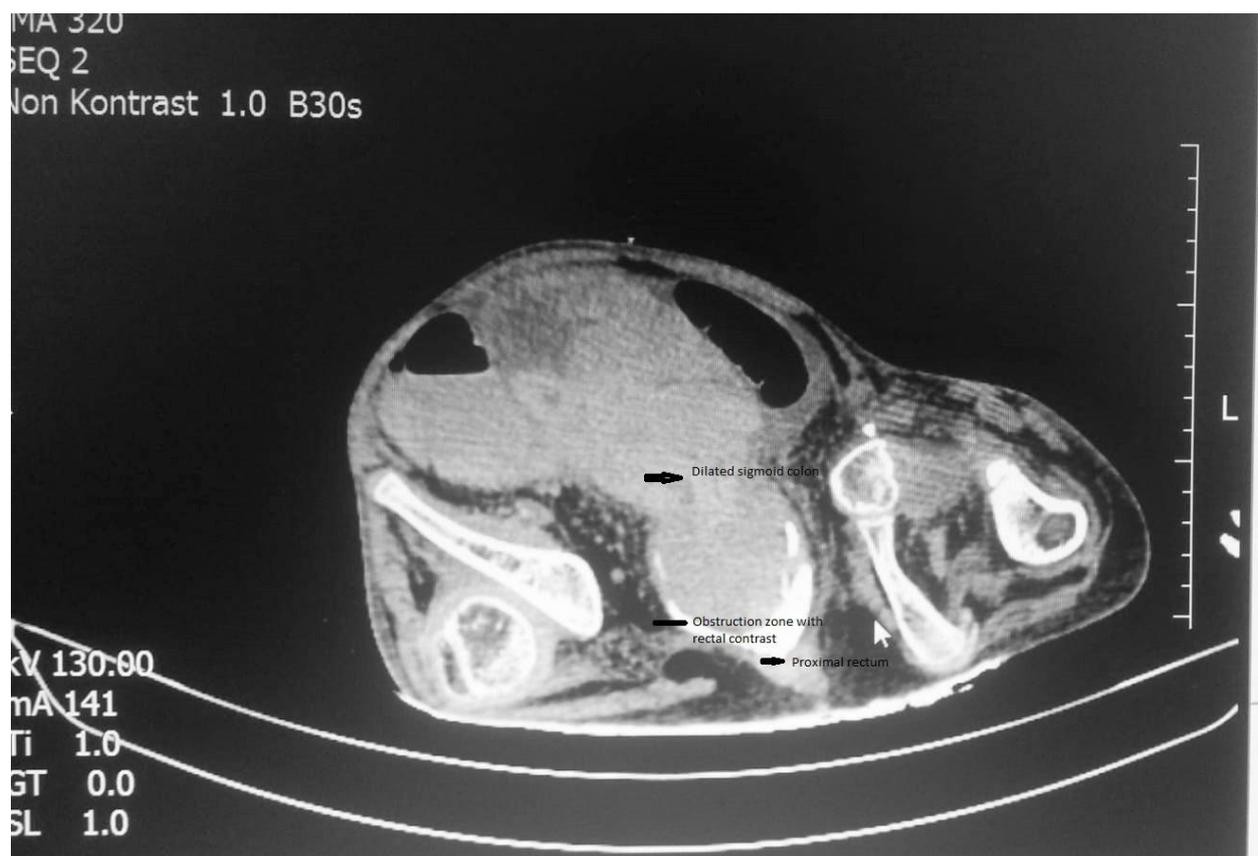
Abdominal CT image of the patient
